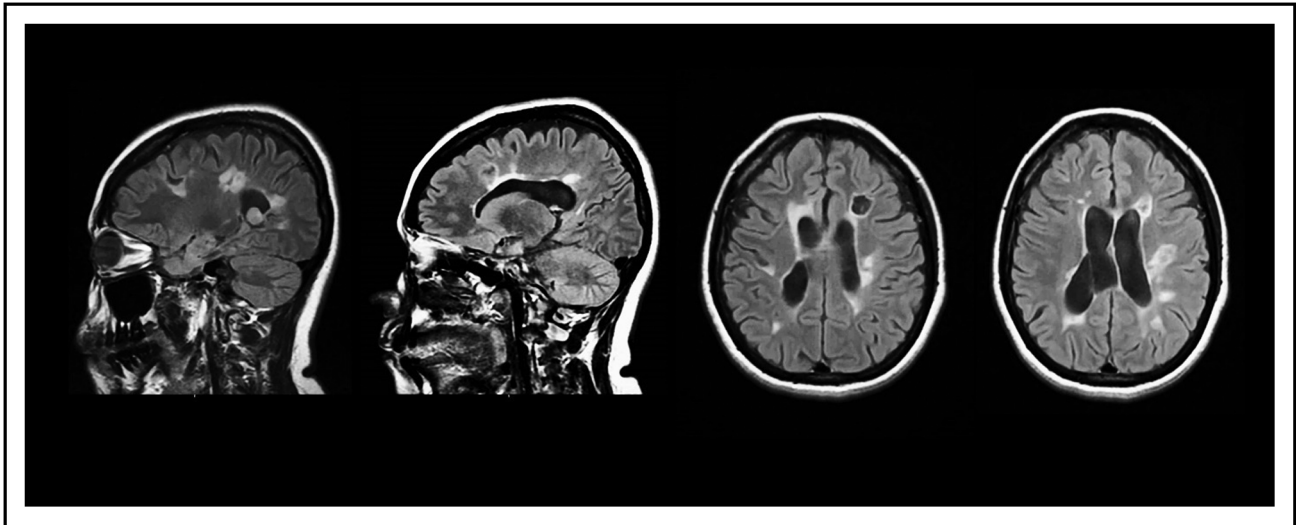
Structural magnetic resonance imaging of a 35-year-old woman with a diagnosis of neuropsychiatric systemic lupus erythematosus, who suffers from cognitive disturbance (verbal and visual memory abnormalities as well as executive dysfunction) leading to academic failure, which prevented her from completing her university education. She also presents a psychopathological pattern characterized by depressive symptoms, affective dysregulation, and suicidal ideation. The T2 FLAIR axial and sagittal projections shows multiple periventricular, hyperintense lesions (the largest one with a hypointense component) on both cerebral hemispheres, which are compatible with chronic ischaemic changes.
